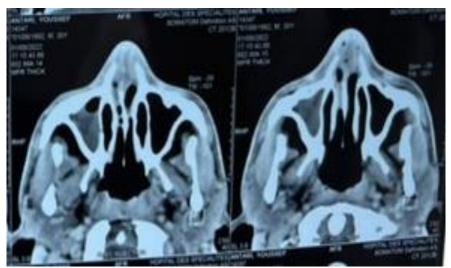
Axial section naso-sinus CT scan showing septal abscess
